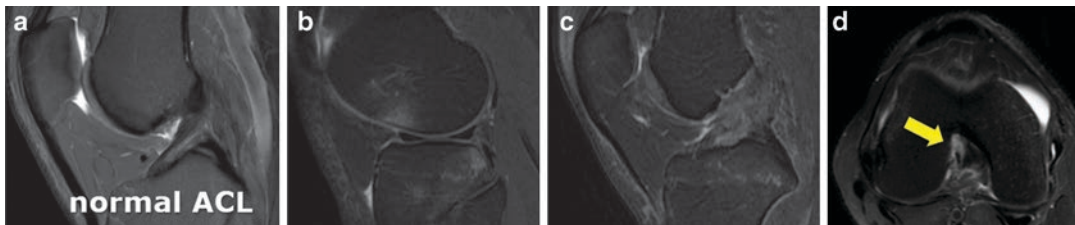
T2 Fat Sat MRI sagittal views of the Knee. (a) Normal ACL, (b) bone contusions in the lateral compartment, (c) complete tear of the ACL, and (d) Empty notch sign in the femoral origin of the ACL (yellow arrow)
